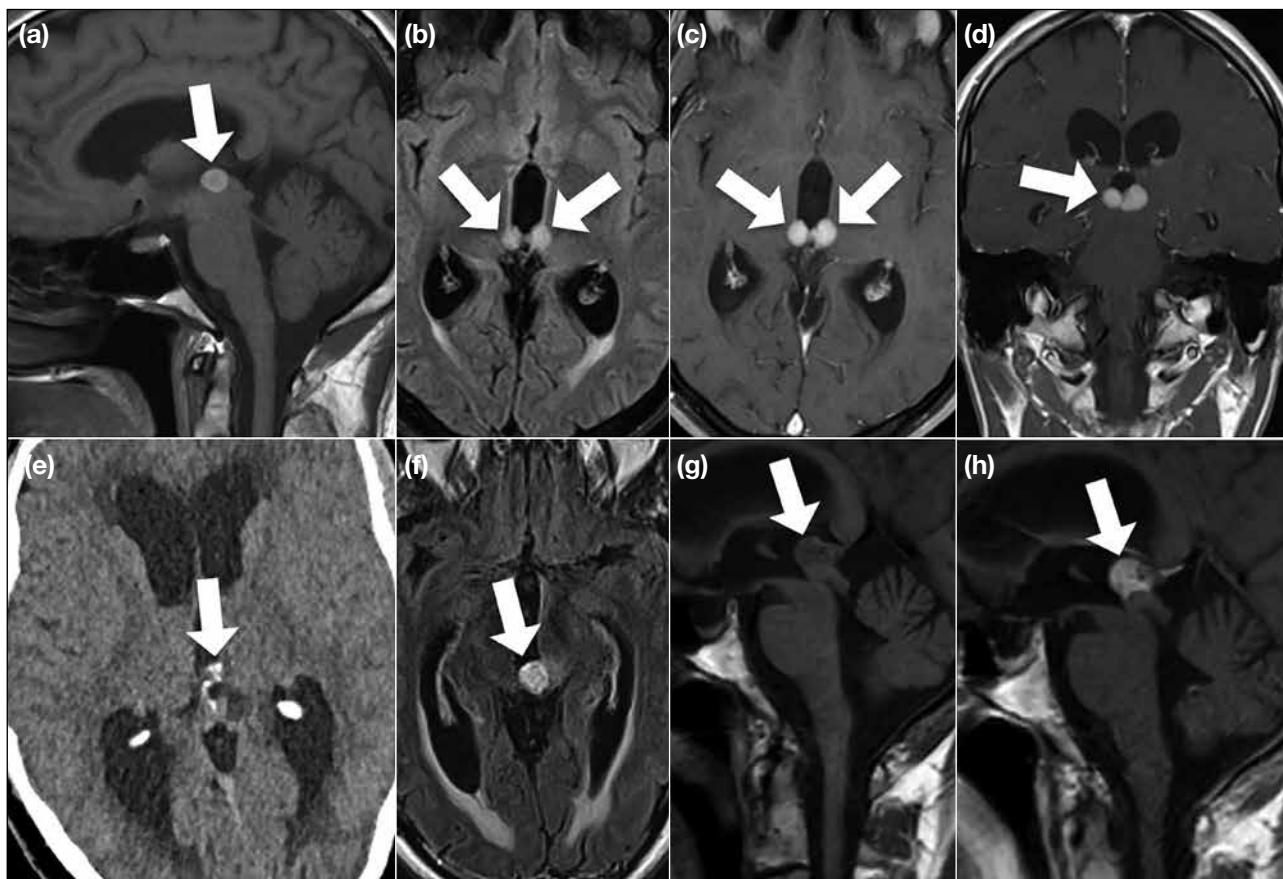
Papillary tumour of the pineal region. Case 1 shows a well-defined bilobulated hyperintense lesion (arrows) in the posterior commissure on sagittal T1-weighted image (a), which is hyperintense on axial T2-weighted fluid-attenuated inversion recovery image (b) and homogeneously enhancing on enhanced axial (c) and coronal (d) T1-weighted images. Case 2 shows a hypodense pineal tumour with probable displacement of the pineal calcification (arrows) to the margin of the gland on the nonenhanced axial computed tomography image (e). The tumour (arrows) is heterogeneously hyperintense on T2-weighted fluid-attenuated inversion recovery image (f) and heterogeneously hypointense on unenhanced (g) and enhancing on contrast-enhanced (h) sagittal T1-weighted images.
